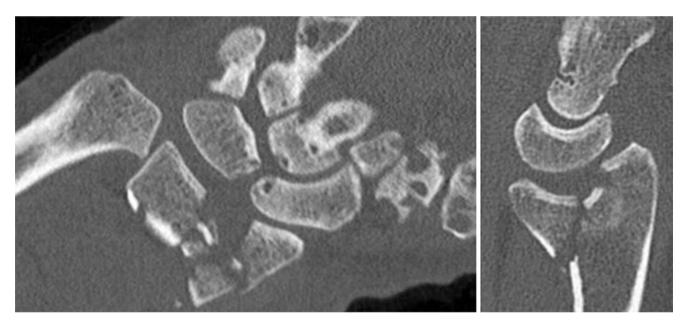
Coronal (left) and sagittal (right) CT images of a comminuted intra-articular distal radius fracture. (Figures from author's library)
